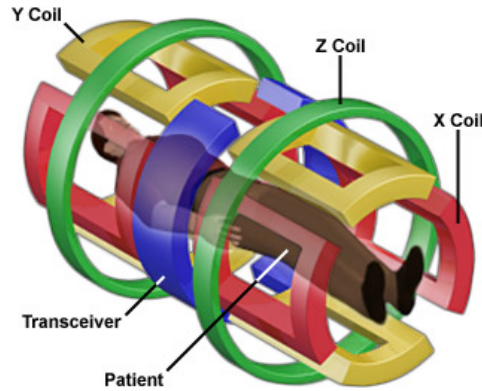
MRI Scanner Gradient Magnets.
